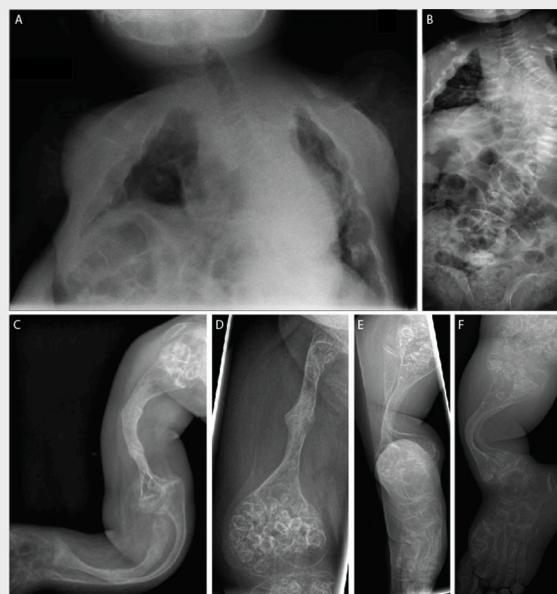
Index patient's radiographs at 11 years before bisphosphonate treatment. She has small, narrow thorax (A) and severe kyphoscoliosis (B) with spinal compression fractures involving the whole spine (B). All long bones in arms (C) and legs (D-F) are short, deformed and osteoporotic. Metaphyseal regions are wide and show "pop-corn"-like irregular calcification (C-F)
